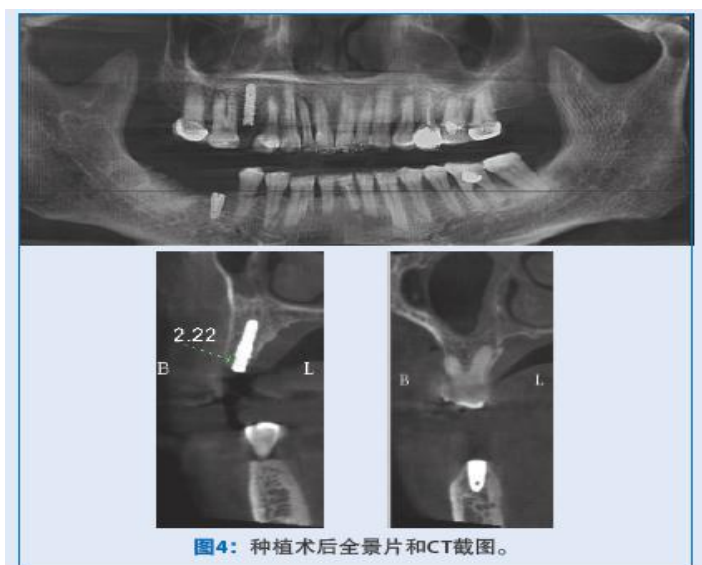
Panoramic radiograph and CT screenshot after implantation.
